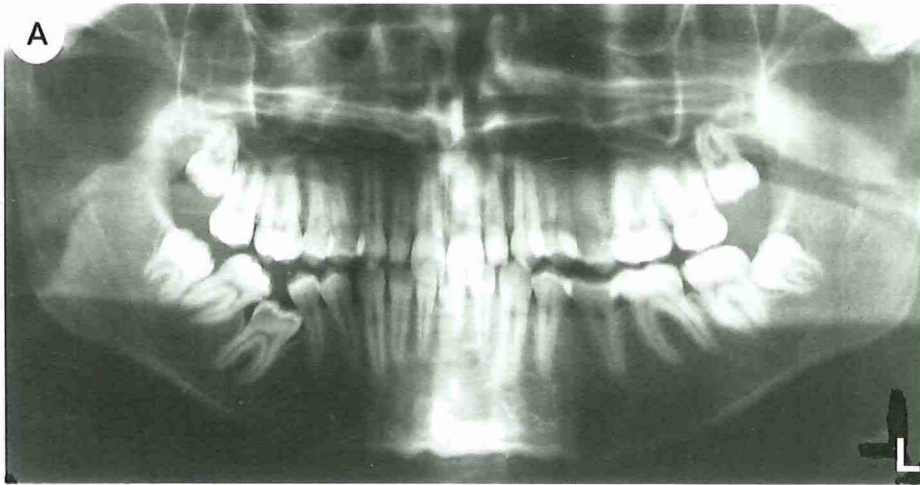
A Orthopantomogram of a 17-year-old boy showing secondary retention of the mandibular right first molar. B Orthopantomogram of the same patient 4 years after removal of the retained molar. The right second molar has tilted toward the second premolar.
